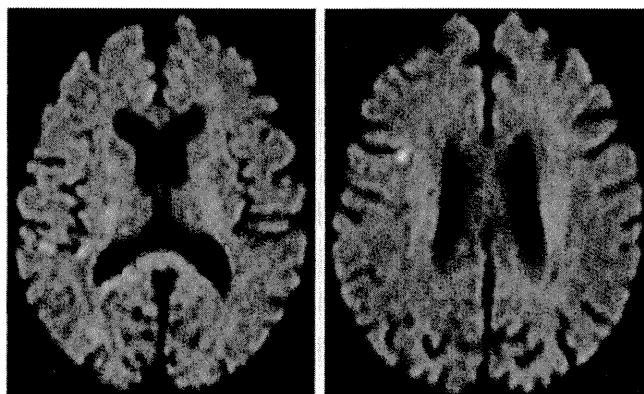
TIA (+) の代表症例 (80 歳, 女性) の DWI
